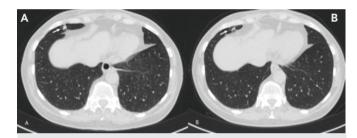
A 71-year-old female who has been followed-up for subcentimetric six nodules underwent non-contrast control computed tomography imaging and (A) showed new 7 mm nodule (arrow) in middle lobe. (B) 9 months later, the nodule decreased in size
